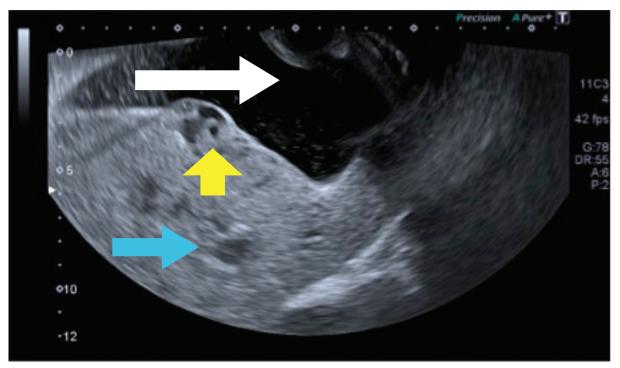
Transabdominal ultrasonographic examination showed focal percreta (yellow arrow), placenta is heterogenous, low lying (blue arrow), bladder (white arrow).
